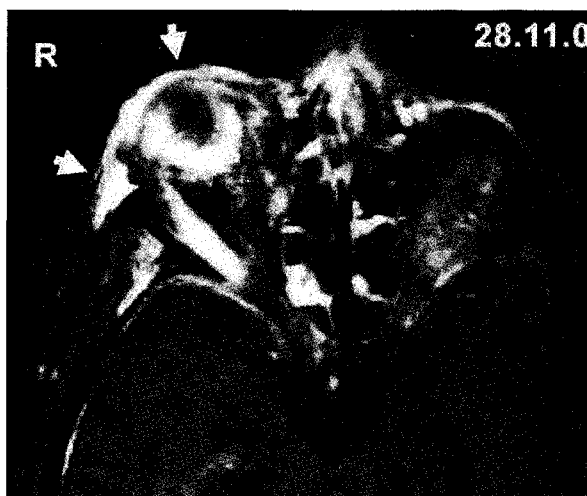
MR image showing diffuse orbital and peri-orbital inflammation with thickened and enhanced episcleral tissue. Spread of infection towards the orbital apex is well demonstrated
